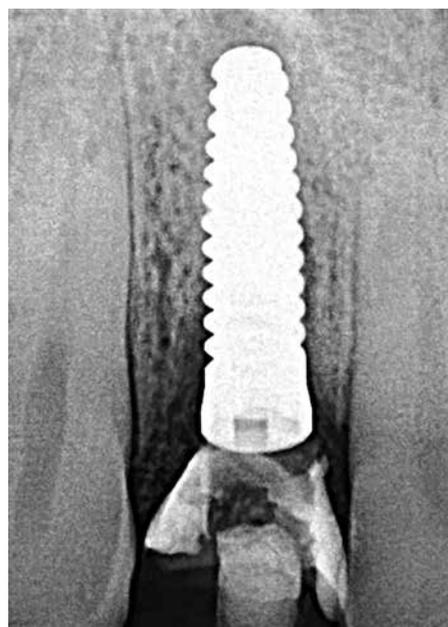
Periapical radiograph of the immediate placed zirconia implant (ZERAMEX) and provisional restoration at the time of surgical placement
